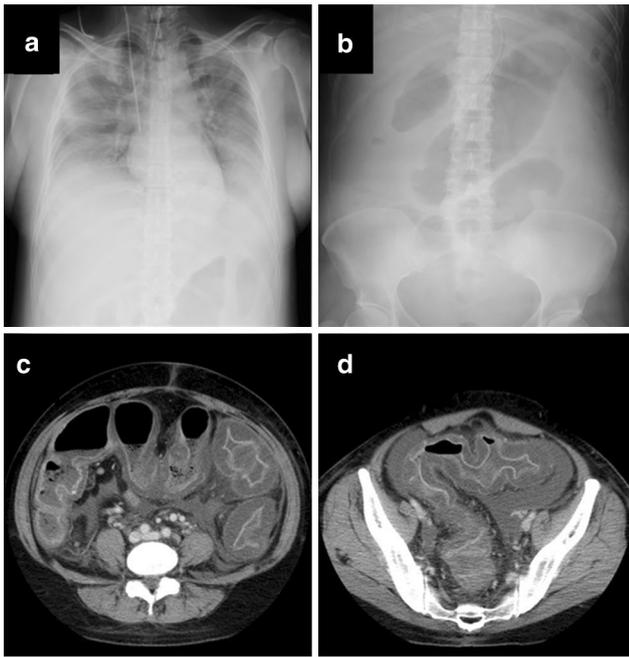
X-ray and CT findings: a pleural effusion was observed. b The transverse colon expanded to a diameter of 8 cm. c, d Ascites and marked colonic mucosal edema were observed
